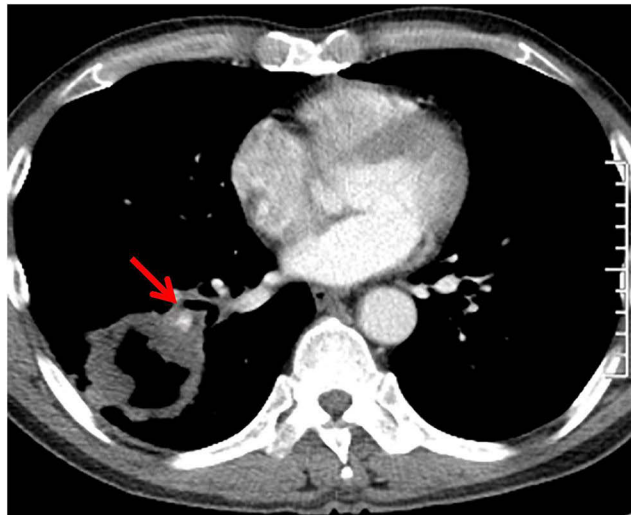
Enhanced chest CT July 15, 2022. Red arrow: pulmonary artery.
